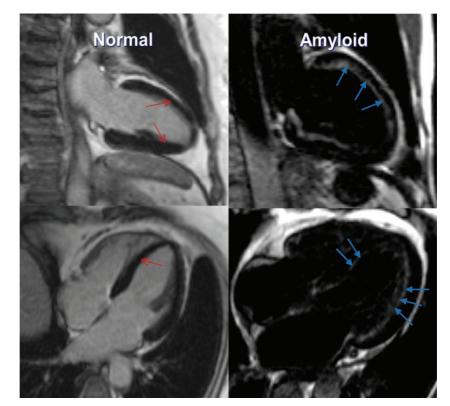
Cardiac magnetic resonance images with late gadolinium enhancement in long axis (vertical) (top) and short axis (horizontal planes) (bottom) in a normal subject and a patient with cardiac AL amyloidosis. In a normal subject (left), signal from the myocardium is nulled and it appears black (-->>) without areas of white contrast that would indicate myocardial fibrosis or amyloidosis. In a patient with cardiac AL amyloidosis (right) using a similar sequence the expanded myocardial extracellular volume leads to nulling of both myocardium, blood pool and diffuse subendocardial enhancements (-->)—which is characteristic of cardiac amyloid infiltration (images, courtesy of Dr Marianna Fontana and Dr James Moon, Heart Hospital, UCL, London).
